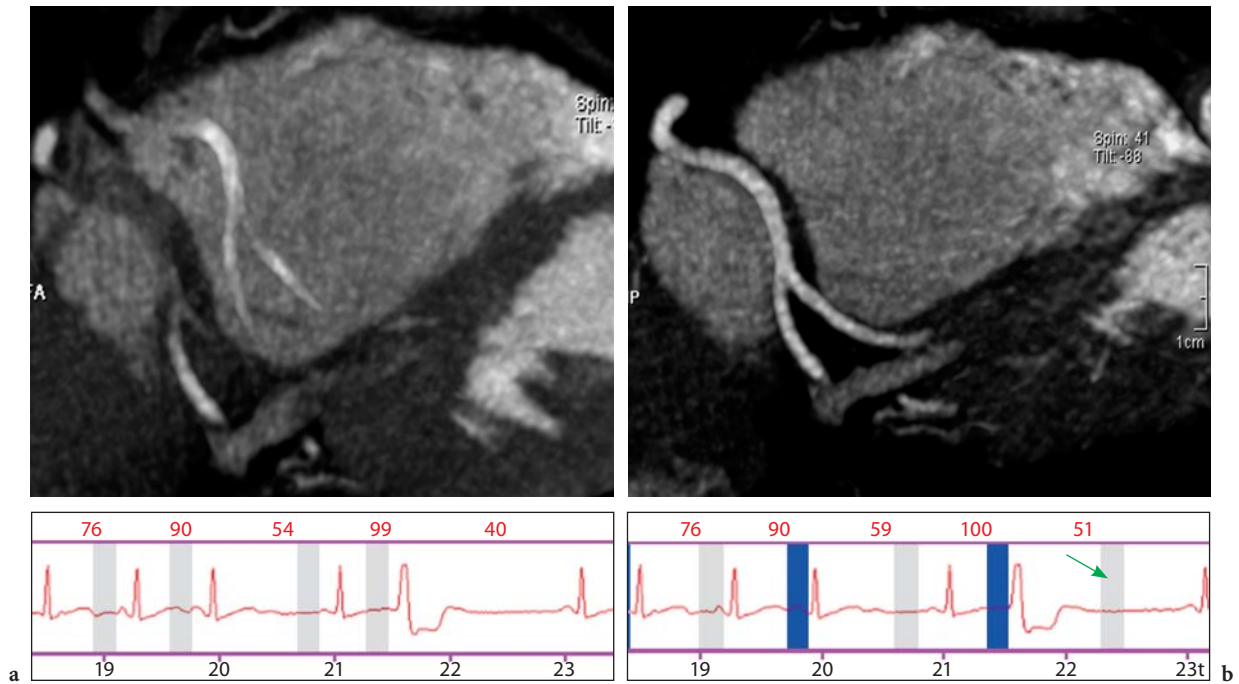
Case example of a patient scanned with a 64-slice CT scanner. The patient had extra-systolic beats during the scan. The scan was acquired using a slice acquisition of 64×0.6 mm and a rotation time of 0.33 s. Misregistration artifacts can be strongly reduced and the diagnostic quality of the study restored via interactive elimination of the extra heart beats before image reconstruction. In this case, an extra-systolic beat strongly compromises visualization of the distal right coronary artery (a). After interactive elimination of those reconstruction intervals affected by the extra-systolic beat (blue bars) and manual introduction of alternative image reconstruction intervals (gray bars, green arrow), image quality could be fully restored (b). (Case courtesy of New York University, USA)
